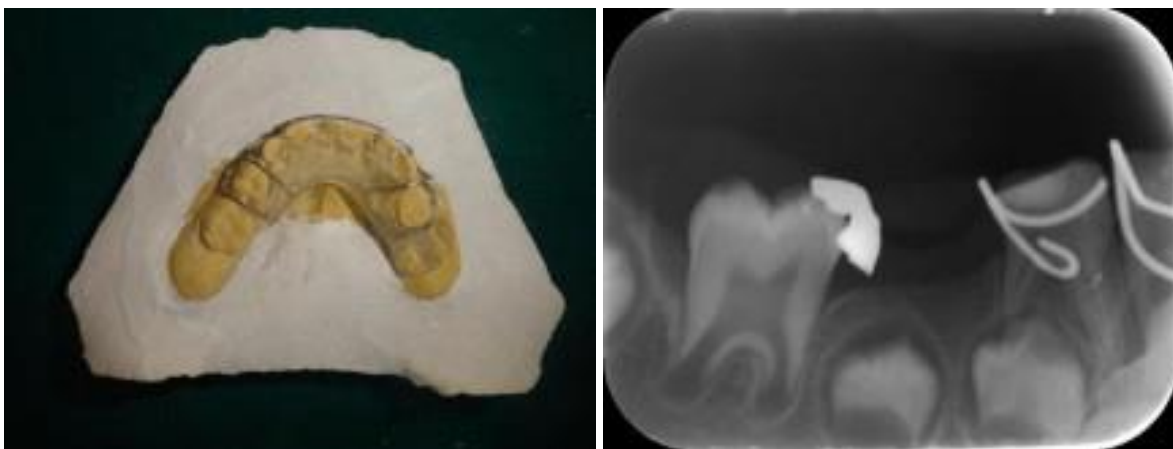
Acrylic resin plate showing extent of the distal shoe space maintainer clinically and radiographically
